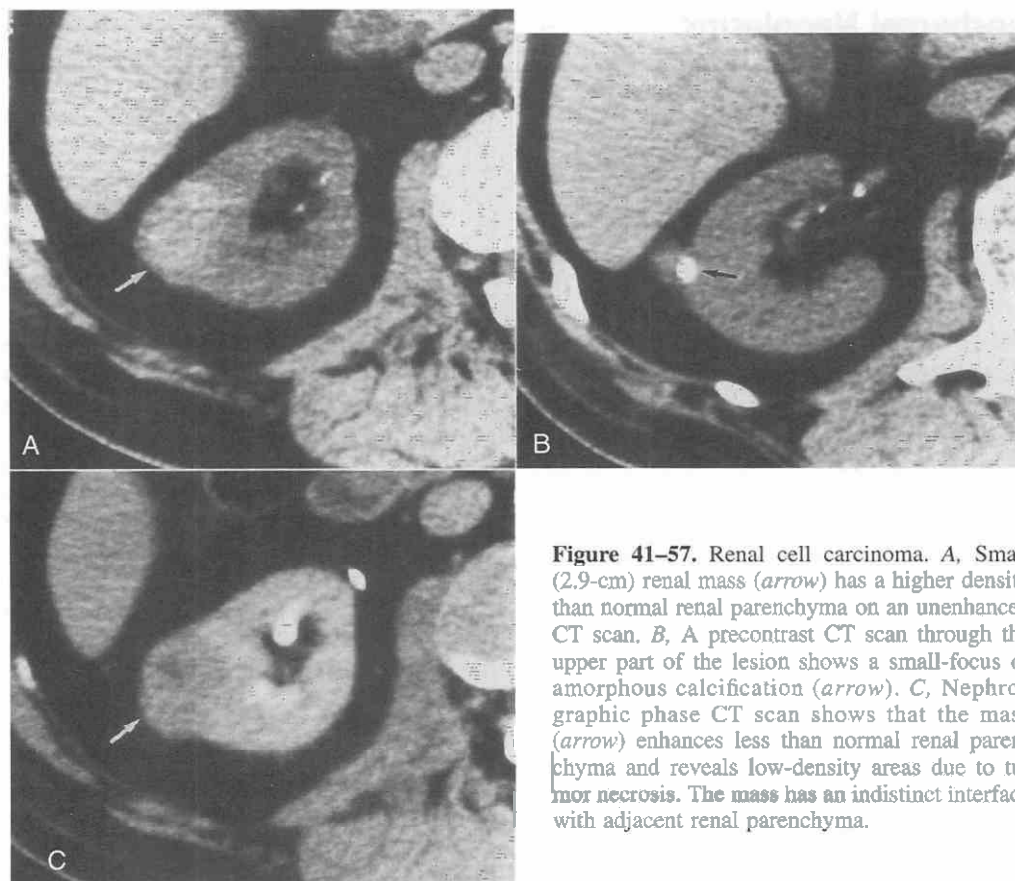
Renal cell carcinoma. *A*, Small (2.9-cm) renal mass (*arrow*) has a higher density than normal renal parenchyma on an unenhanced CT scan. *B*, A precontrast CT scan through the upper part of the lesion shows a small-focus of amorphous calcification (*arrow*). *C*, Nephrographic phase CT scan shows that the mass (*arrow*) enhances less than normal renal parenchyma and reveals low-density areas due to tumor necrosis. The mass has an indistinct interface with adjacent renal parenchyma.
